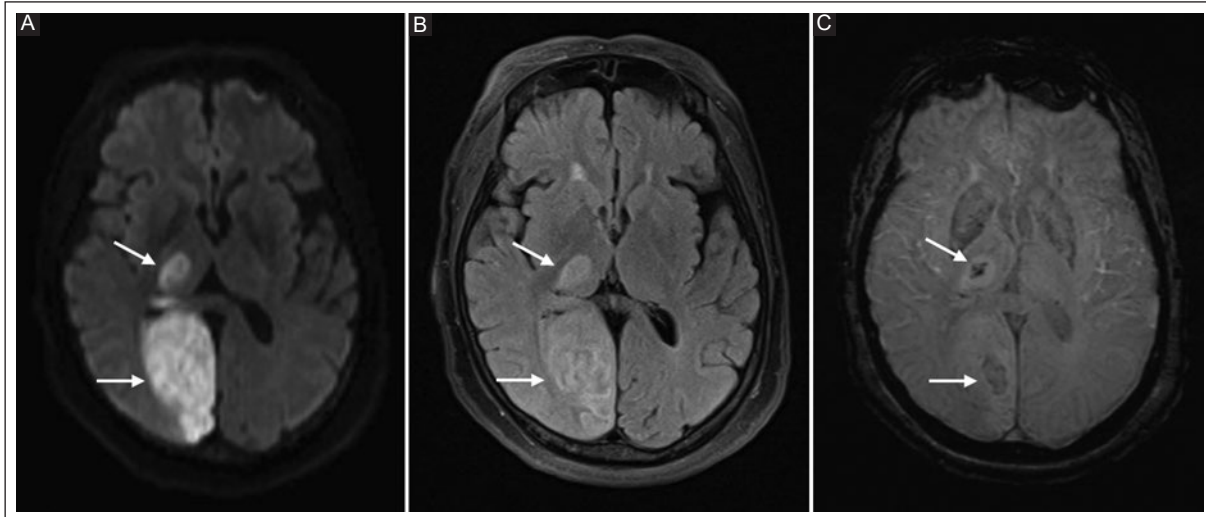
Ultrafast MRI protocol for stroke in axial view in a 69-year-old woman. DWI sequence A: shows an area of restricted diffusion in the distribution of the right posterior cerebral artery territory, visible as a hyperintensity on FLAIR B: consistent with an acute ischemic stroke (arrows). C: SWI sequence shows hypointense foci that represent hemorrhagic transformation within the ischemic stroke area (arrows). The ADC map was calculated from the DWI sequence; the filtered phase and MIP are derived from SWI (not shown).
